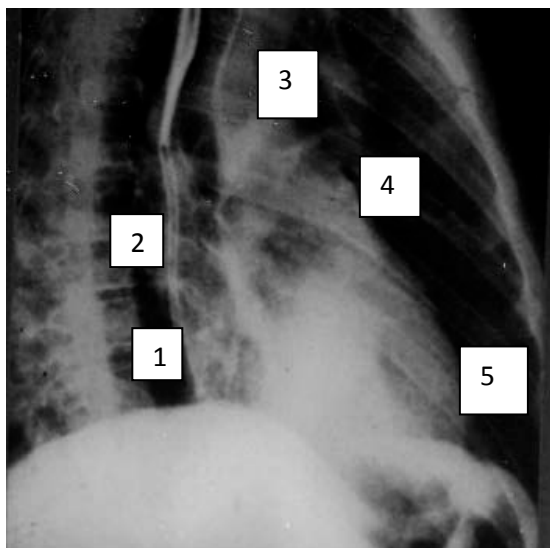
The heart radiograph in the right (first) oblique projection. The contrasted oesophagus settles down rectilinearly. 1 – arches of the right atrium, 2 – arch of the left atrium, 3 – arch of an ascending aorta, 4 – arch of the pulmonary cone, 5 – left ventriculus arch. Norm [31]
